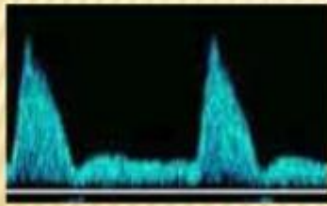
Doppler waveforms of uterus artery in the 3 trimesters
